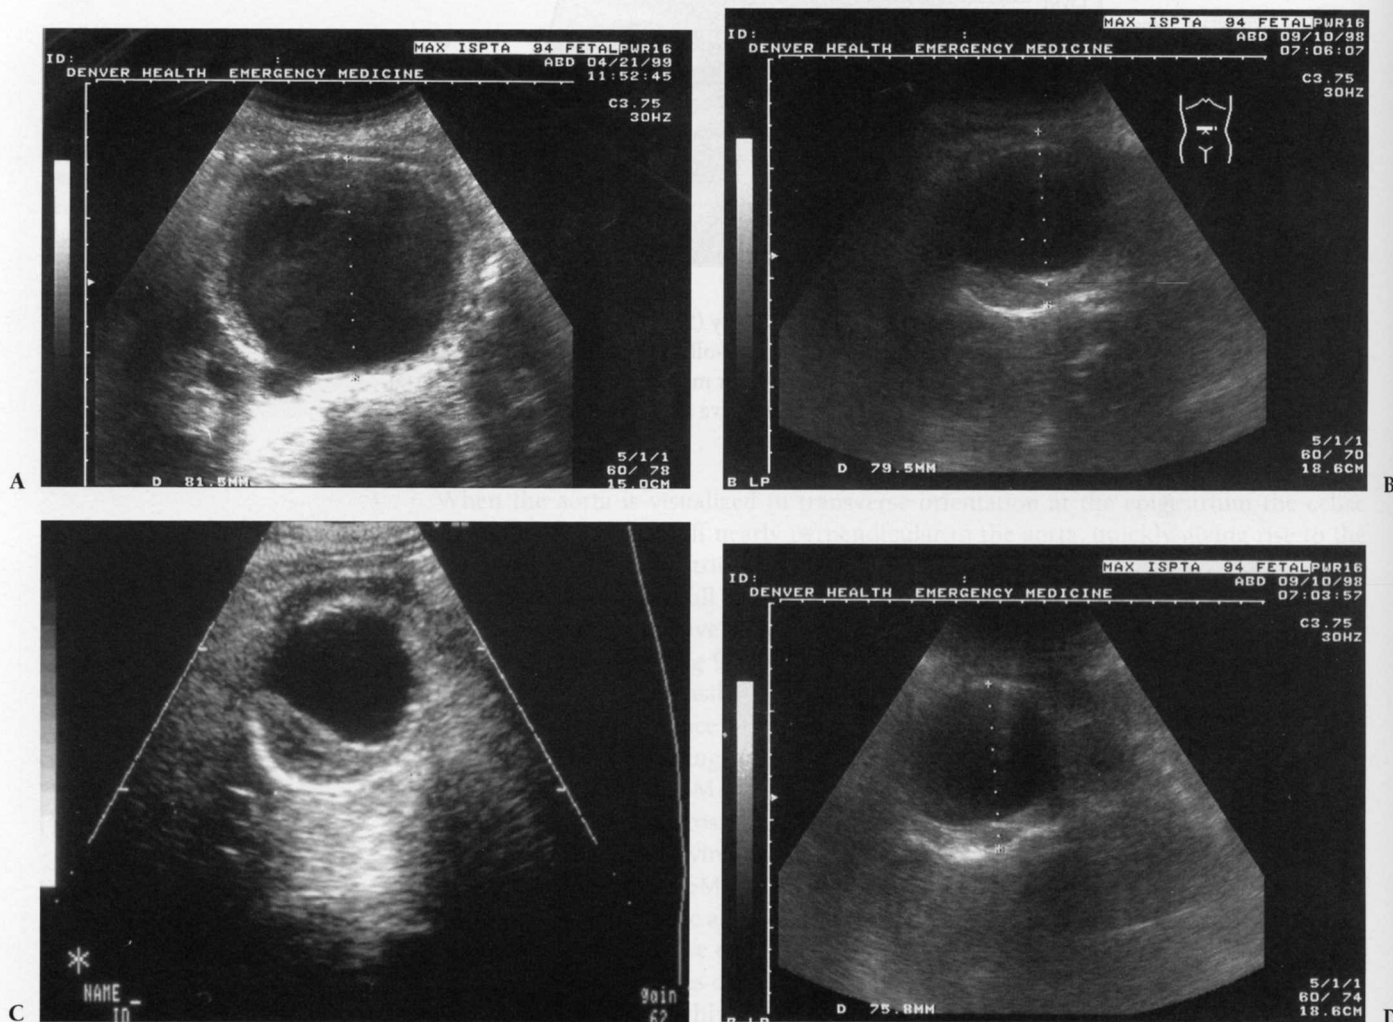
Ultrasound images of a variety of abdominal aortic aneurysms (A, B, C, and D). (Reused with permission from *Ultrasound in Emergency Medicine and Trauma* © 2005, Challenger Corporation.)
